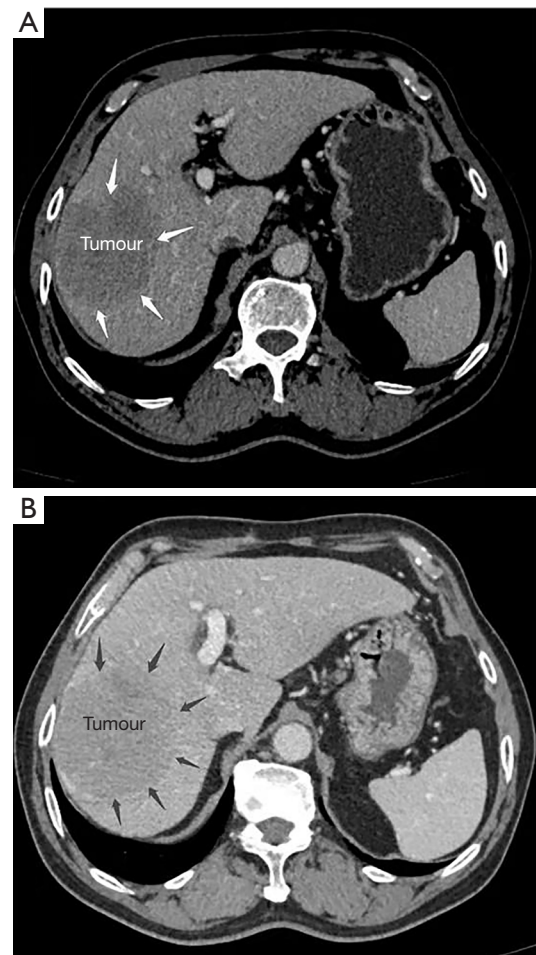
CT scan of the upper abdomen revealed the lesion to be located primarily in the right liver, about 10.1 cm × 8.4 cm in size, and consistent with the imaging features of the hepatocellular carcinoma. (A) Arterial phase; (B) portal venous phase. The arrows indicate the boundary of tumour.
